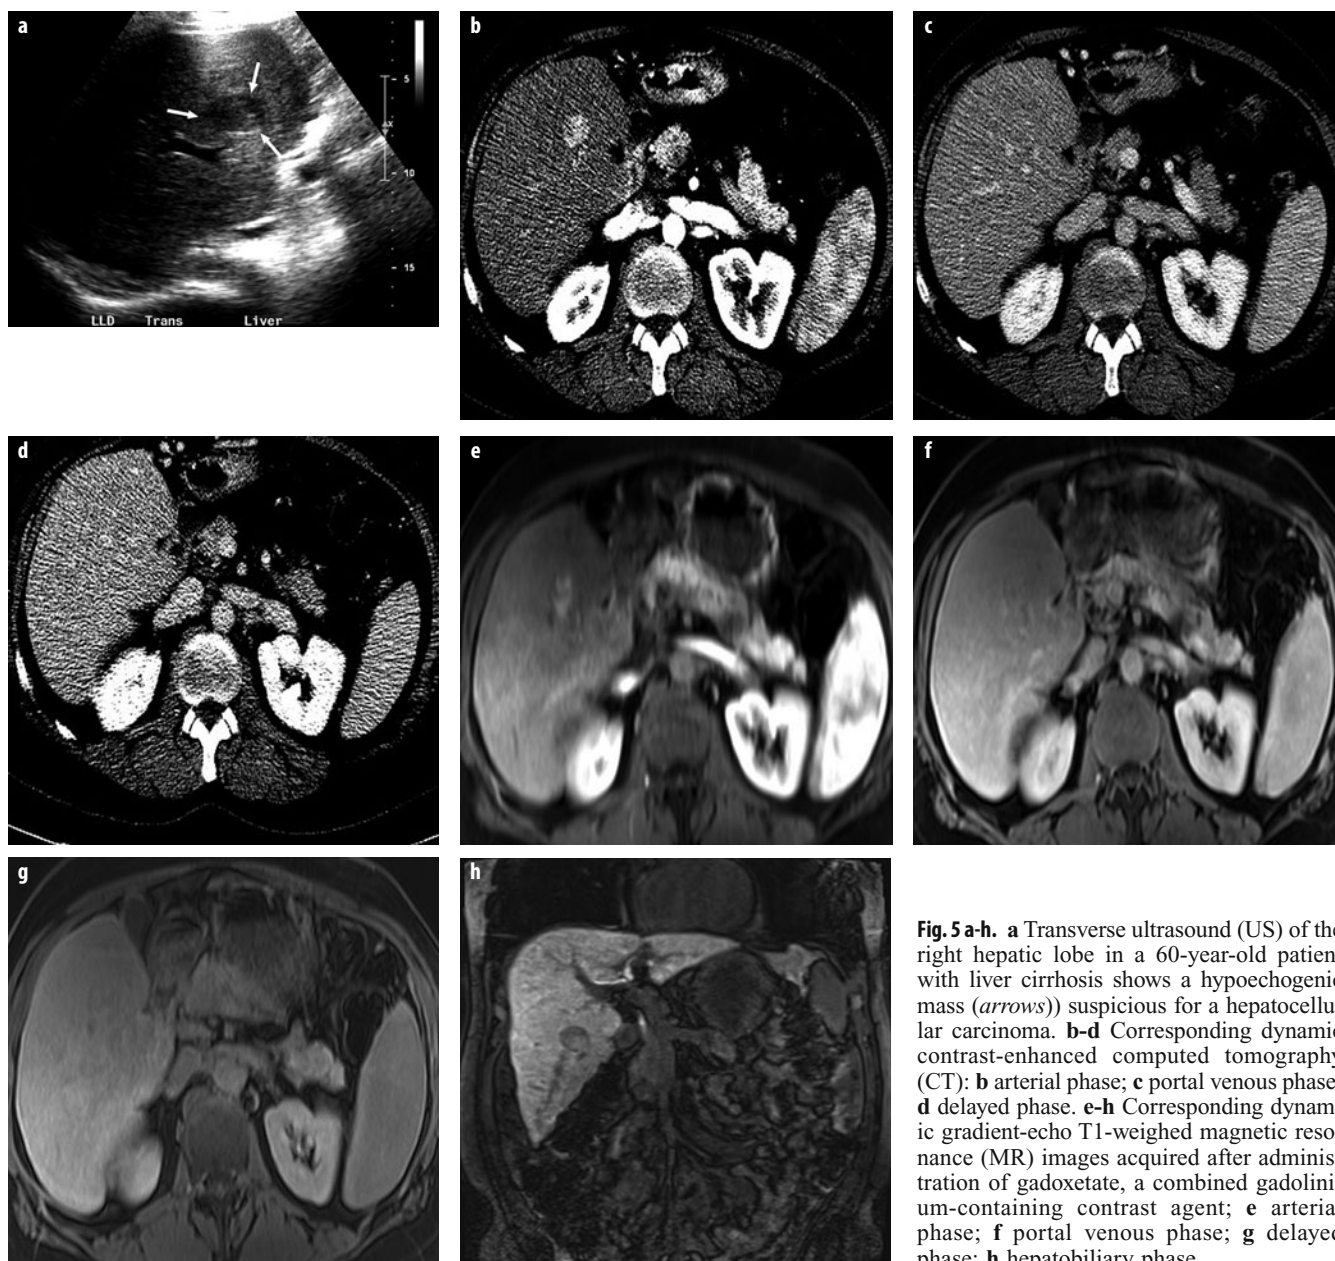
a-h. a Transverse ultrasound (US) of the right hepatic lobe in a 60-year-old patient with liver cirrhosis shows a hypoechoic mass (*arrows*) suspicious for a hepatocellular carcinoma. b-d Corresponding dynamic contrast-enhanced computed tomography (CT): b arterial phase; c portal venous phase; d delayed phase. e-h Corresponding dynamic gradient-echo T1-weighted magnetic resonance (MR) images acquired after administration of gadoxetate, a combined gadolinium-containing contrast agent; e arterial phase; f portal venous phase; g delayed phase; h hepatobiliary phase
